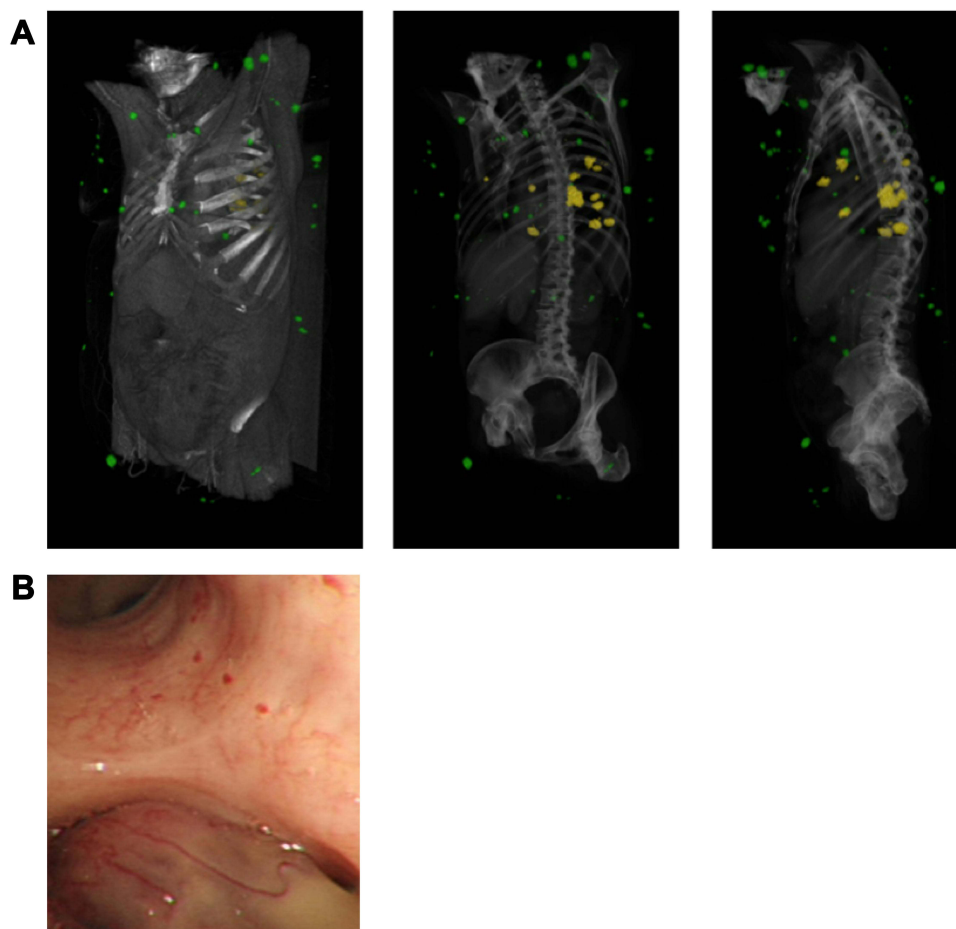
Pulmonary and cutaneous cylindromas visualised radiologically and endoscopically. (A) Spatial location of cutaneous CCS tumours seen on a CT with contrast indicated in green, and pulmonary CCS tumours indicated in yellow. Adapted from (B) Intra bronchial CCS tumour visualised during bronchoscopy. Adapted with permission from Brown SM, Arefi M, Stones R, et al. Inherited pulmonary cylindromas: extending the phenotype of *CYLD* mutation carriers. *Br J Dermatol.* 2018;179:662–668. © 2018 The Authors. *British Journal of Dermatology* published by John Wiley & Sons Ltd on behalf of British Association of Dermatologists.⁴¹
